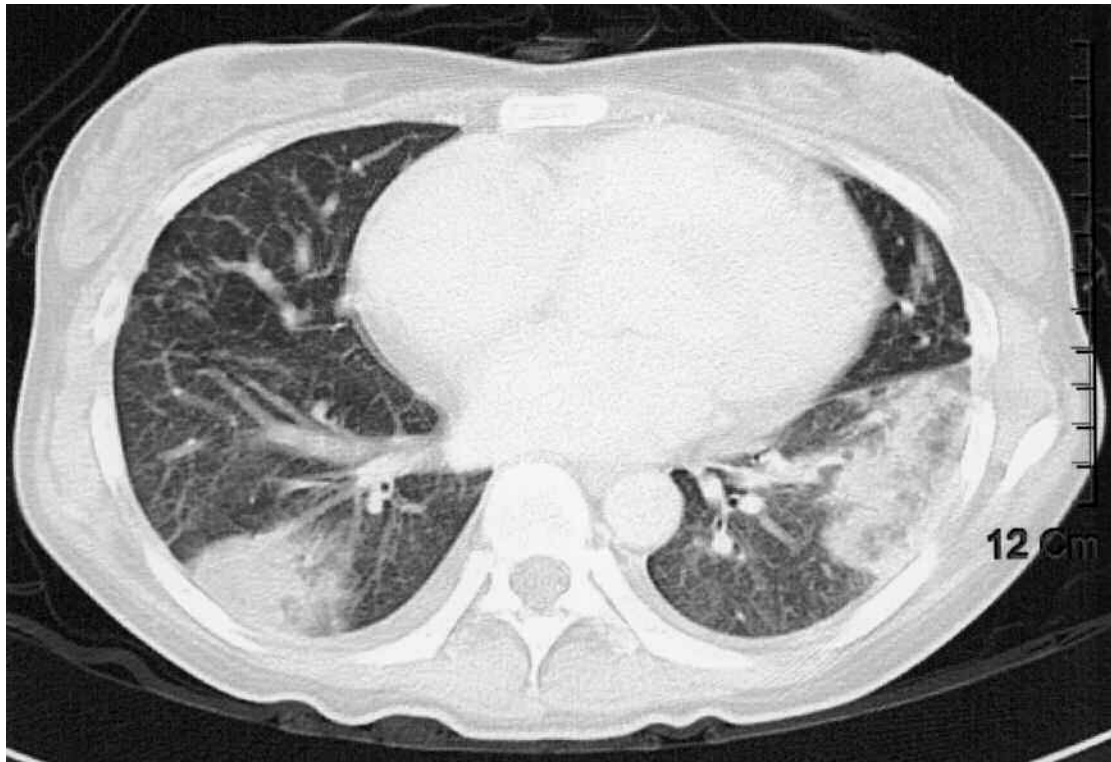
CT revealed wedge-shaped consolidations over bilateral lower lung lobes.
